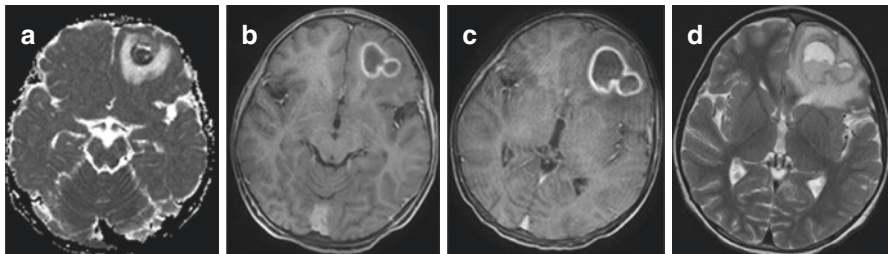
5-year old with cardiogenic abscess (He had Tetralogy of Fallot for which he had undergone a palliative bypass at infancy) presented with seizure (a) The cellular pus in the centre of the abscess produces a low ADC value, and DWI shows diffusion restriction with central bright signal (b) With the contrast-enhanced axial MRI, he underwent conservative management (c), (d) The size increased on conservative management when he underwent excision as it was thick-walled and was penetrable for aspiration. The culture was negative, but his molecular diagnostics identified Strep. milleri and Mycobacterium for which underwent treatment
